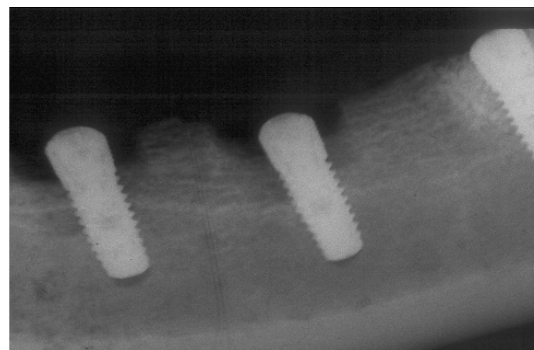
Radiographic view of the experimental site.
